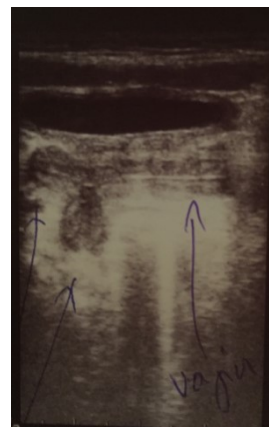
Ultrasound after surgery
